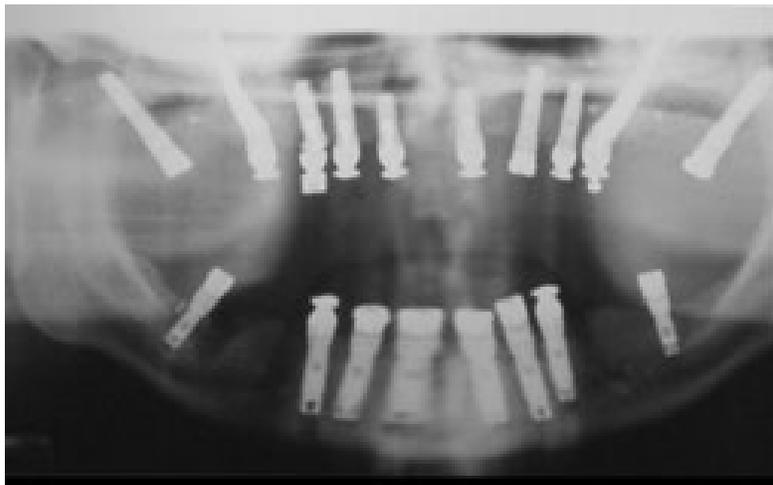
Post-surgical panoramic radiograph of 10 implants in the maxilla and 8 implants in the mandible, all with abutments and cylinders supporting the prostheses.
